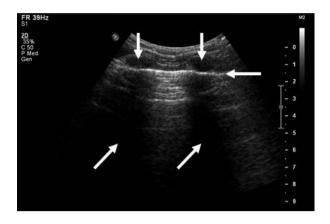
Ultrasound scan of a normal lung, using convex probe. Two adjacent ribs (vertical arrows) with acoustic shadows below (oblique arrows) and hyperechogenic pleural line (horizontal arrow) creating 'the bat sign'
